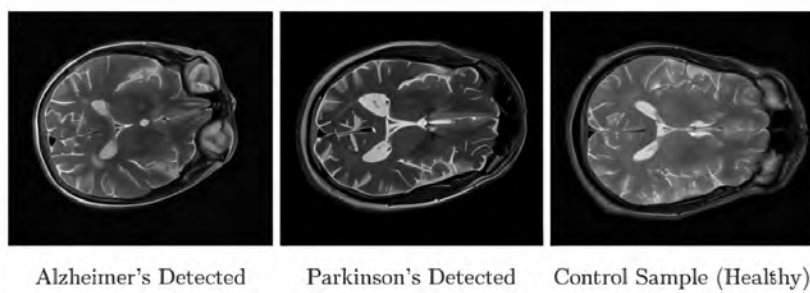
Sample 2D slices of AD, PD, and Healthy MRI scans
